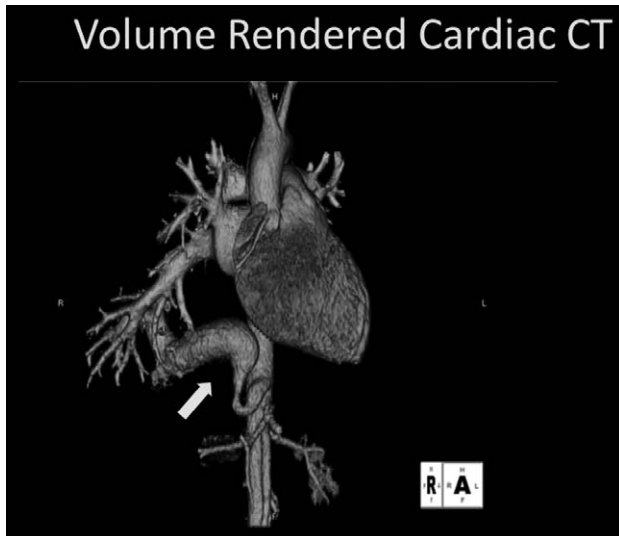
Volume-rendered cardiac computed tomography revealing the presence of a fistula (arrow) between the abdominal aorta and the right inferior pulmonary vein.
